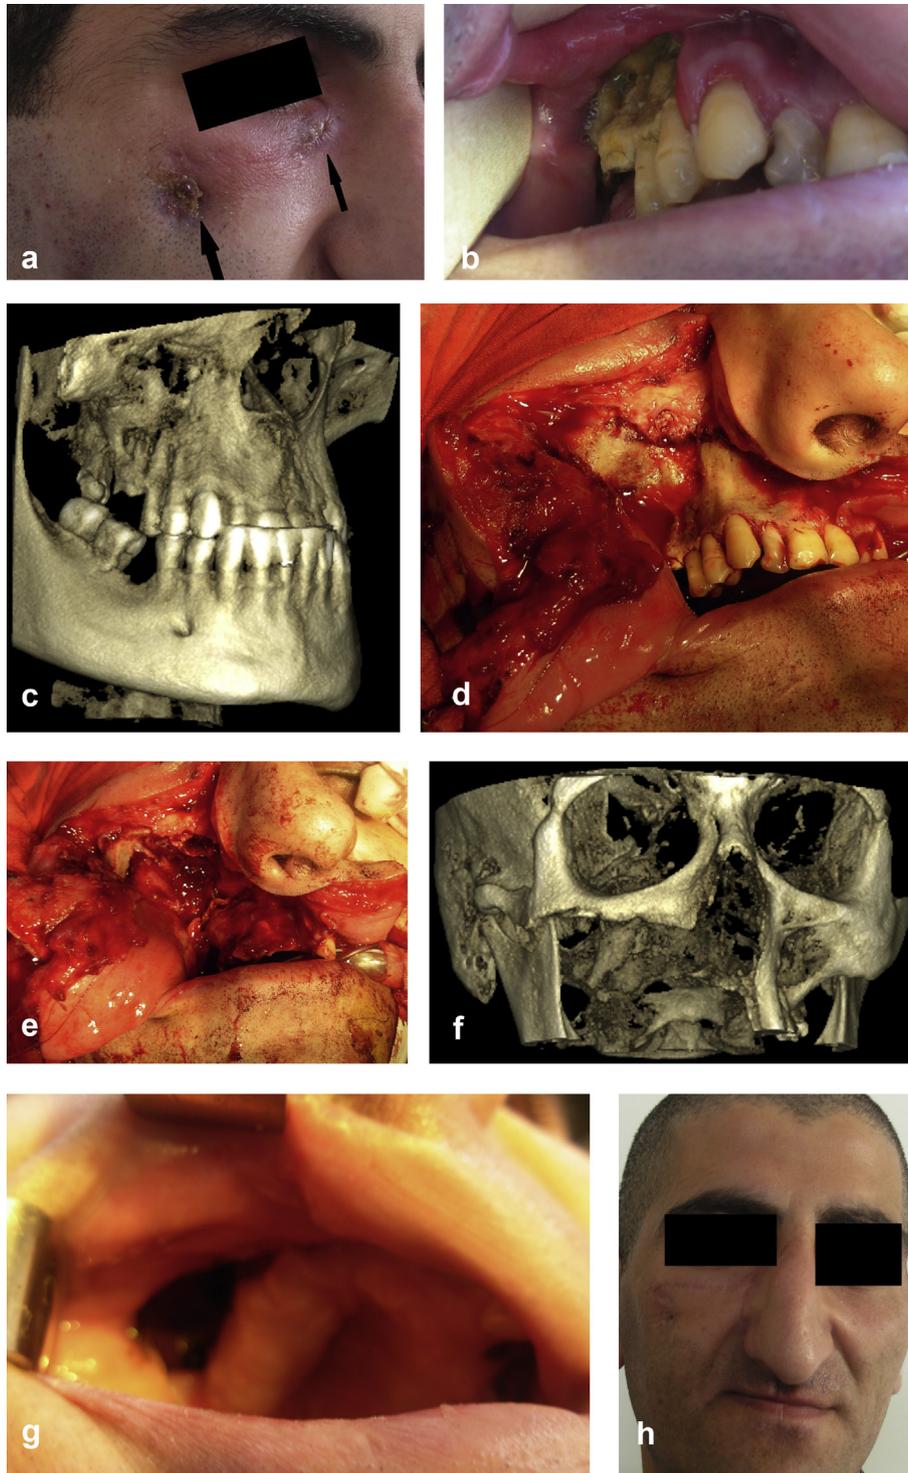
Case 1. Patient with Krokodil drug - related ON of right midface a) extraoral view of the patient, fistulas with purulent discharge are shown (black arrows); b) intraoral exposure of distal maxillary alveolar process; c) preoperative 3D reconstruction of CBCT images, clear demarcation is seen; d) intraoperative view, clear demarcation of necrosis zone is seen; e) intraoperative view after surgical resection, large defect of right midface is seen; f) postoperative 3D reconstruction of CBCT images, large defect of right midface is seen; g) 8 month postoperative intraoral view, large oroantral communication is seen, without ON recurrence; h) 8 month postoperative extraoral view, no signs of disease recurrence are seen.
